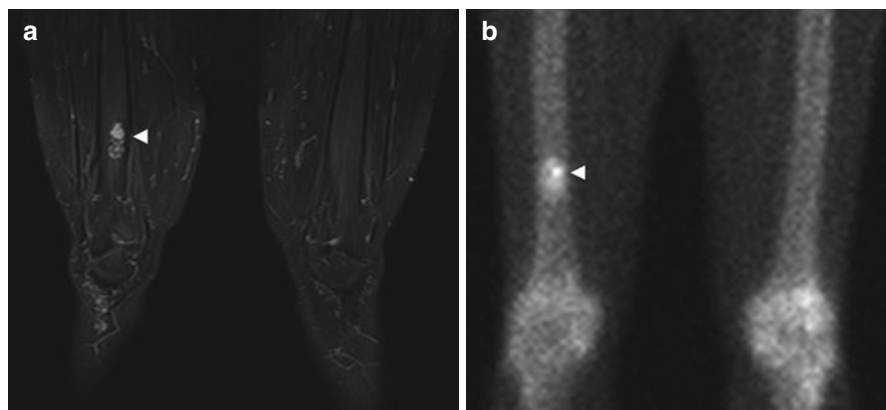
Incidental screening finding (STIR) and diagnostic workup. Forty-five-year-old male subject with a sharply demarcated, lobulated lesion of high signal intensity (*arrowhead*) in the right distal femoral shaft (a). Diagnostic workup with scintigraphy and contrast-enhanced MRI. Tc-99m scan demonstrates high metabolic activity of the lesion (*arrowhead*) (b). On supplementary MRI, the lesion has the characteristic appearance of an enchondroma: hyperintense cartilage surrounded by a thin rim of hypointense perichondrium (*arrowhead*) (sagittal T2w TSE) (c) with a strong peripheral ring-and-arc pattern of enhancement (*arrowhead*) on axial contrast-enhanced image (T1w TSE) (d)
